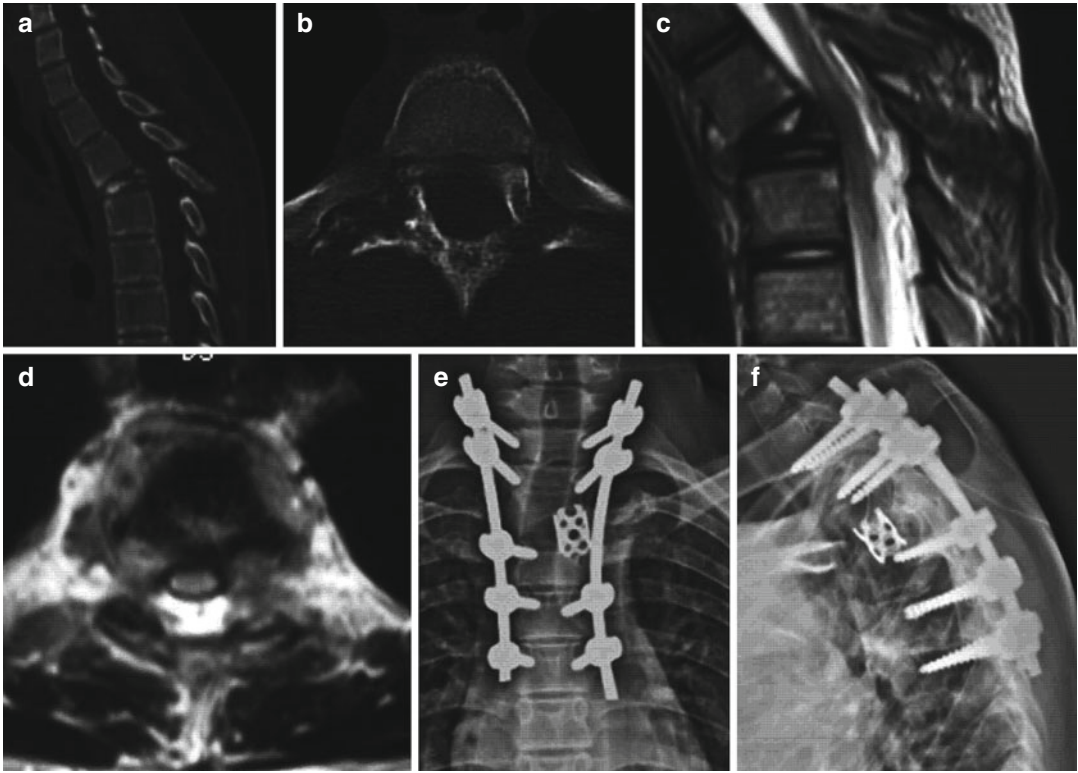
Centrum (complete) type of tuberculosis in a 10-year-old child. Sagittal CT (a) and coronal CT (b) images show complete collapse of the T3 vertebra with involvement of the pedicles and lamina on the right side. Sagittal and axial MRI images (c, d) show complete collapse of the T3 vertebral body with prevertebral abscess
